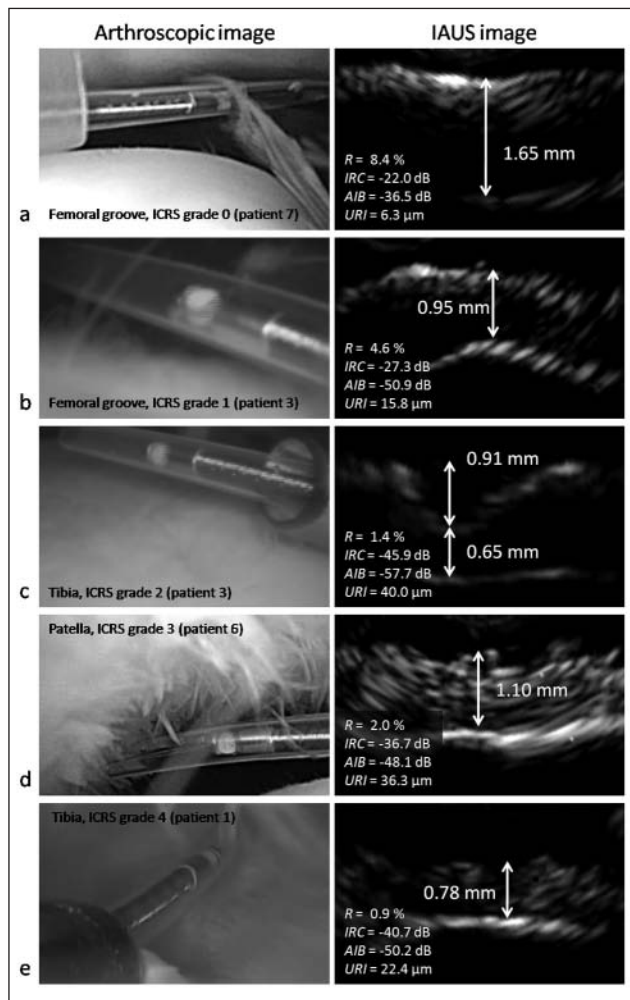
Arthroscopic and ultrasonic images of articular surfaces in the human knee joints. The diameter of the ultrasound catheter (visible in the arthroscopic images) is 1 mm. The International Cartilage Repair Society (ICRS) grade addressed to each measurement site is shown on the arthroscopic images. The dimensions of the intra-articular ultrasound (IAUS) images are 2.5×4 mm. In the IAUS images, the direction of the incident ultrasonic signal is from the physiological saline (above) to the articular cartilage (below). The quantitative ultrasound parameters calculated using the ultrasonic signal are shown on the IAUS images. R = reflection coefficient; IRC = integrated reflection coefficient; AIB = apparent integrated backscatter; URI = ultrasound roughness index.
